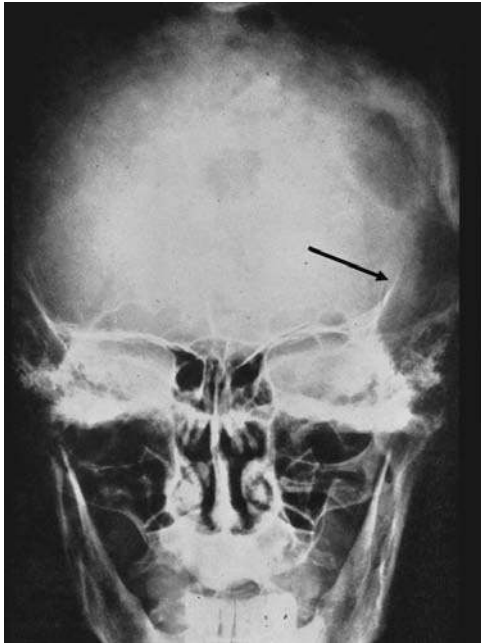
Plain film of Paget's disease showing the radiolucent and radiopaque lesions. The left occipital bone has developed an osteosarcoma (arrow).
